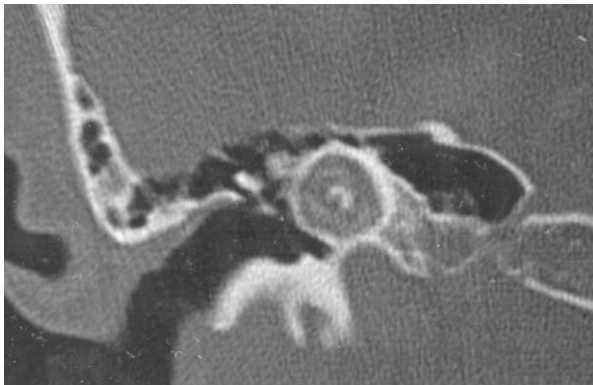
Preoperative CT scan right ear (coronal view): type 3 (unrecognizable otic capsule)
